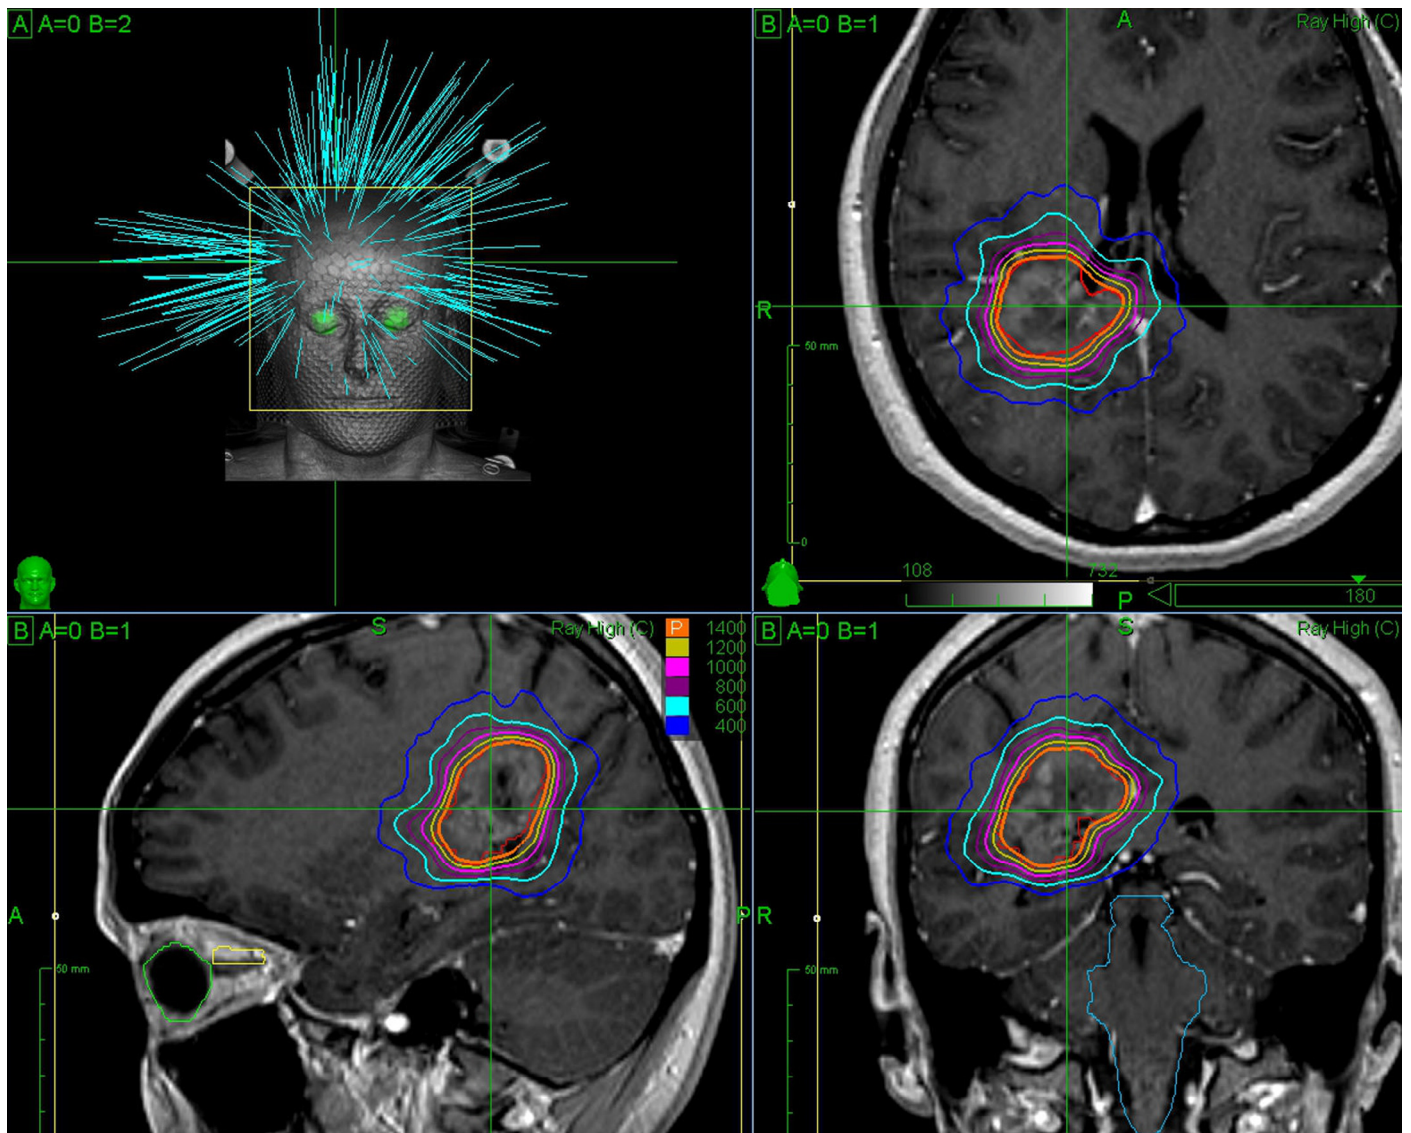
A print screen of the CyberKnife treatment plan delivered to the pregnant patient. The delivered dose distribution is presented in the central axial (upper right), coronal (lower right) and sagittal (lower left) T1 weighted MRI planes in the form of isodose lines. The 3D configuration of the used pencil beams is represented in the upper left panel.
